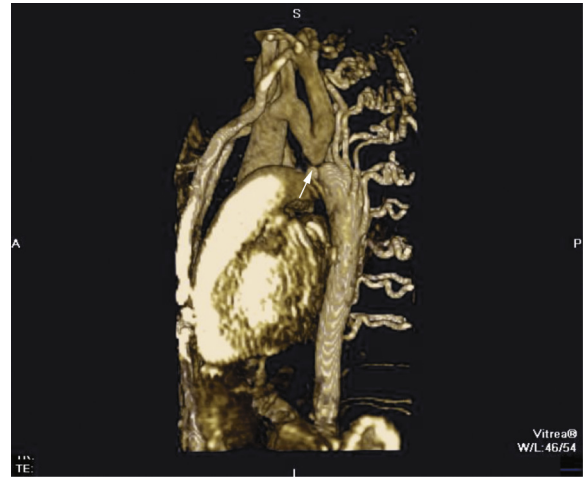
Three-dimensional magnetic resonance image of a coarctation of aorta (*arrow*). Note the numerous collateral arteries to the descending aorta.
